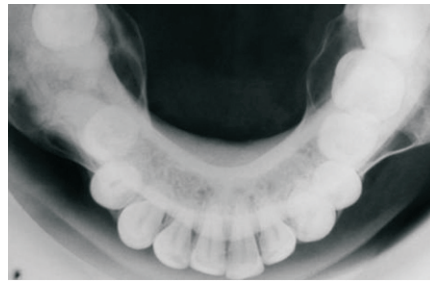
Occlusal radiograph showing expansion and thinning of the buccal and lingual cortex on both sides of the mandible with ground glass appearance.
